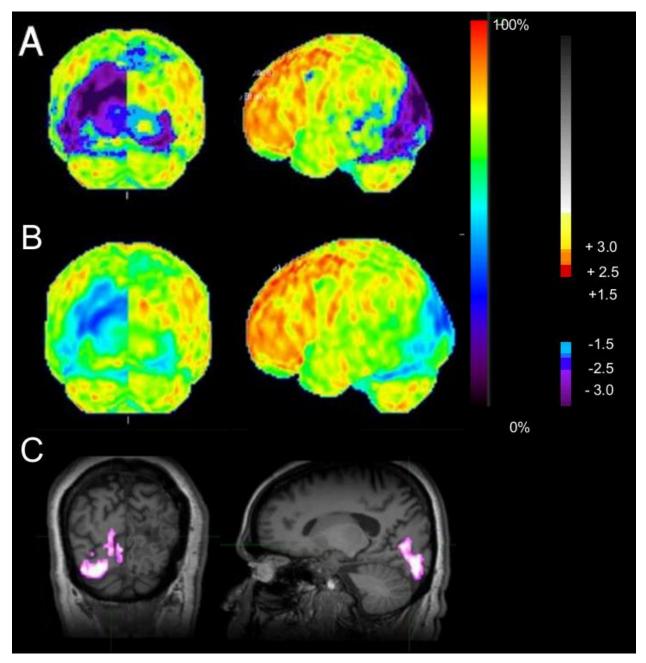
A. Left to Right: z score Stereotactic Surface Projection of <sup>18</sup>F-FDG PET hypometabolism and hypermetabolism and axial Inter-Ictal fused <sup>18</sup>F-FDG PET-MRI. B. Left to Right: z score Stereotactic Surface Projection (SSP) of <sup>18</sup>F-FDG PET hypometabolism and hypermetabolism and axial Ictal fused <sup>18</sup>F-FDG PET-MRI. C. Subtraction fused <sup>18</sup>F-FDG PET-MRI in all 3 planes showing two sites of clusters of significance in the left frontal and left parieto-occipital lobe.
